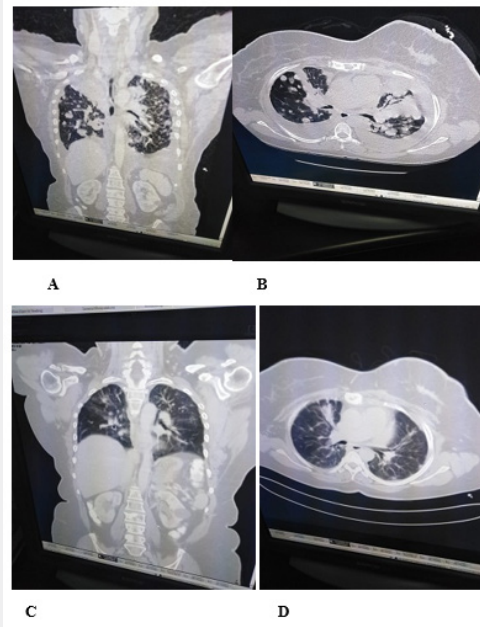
CT chest with contrast, Pre-treatment (A,B) and post treatment (C,D).
